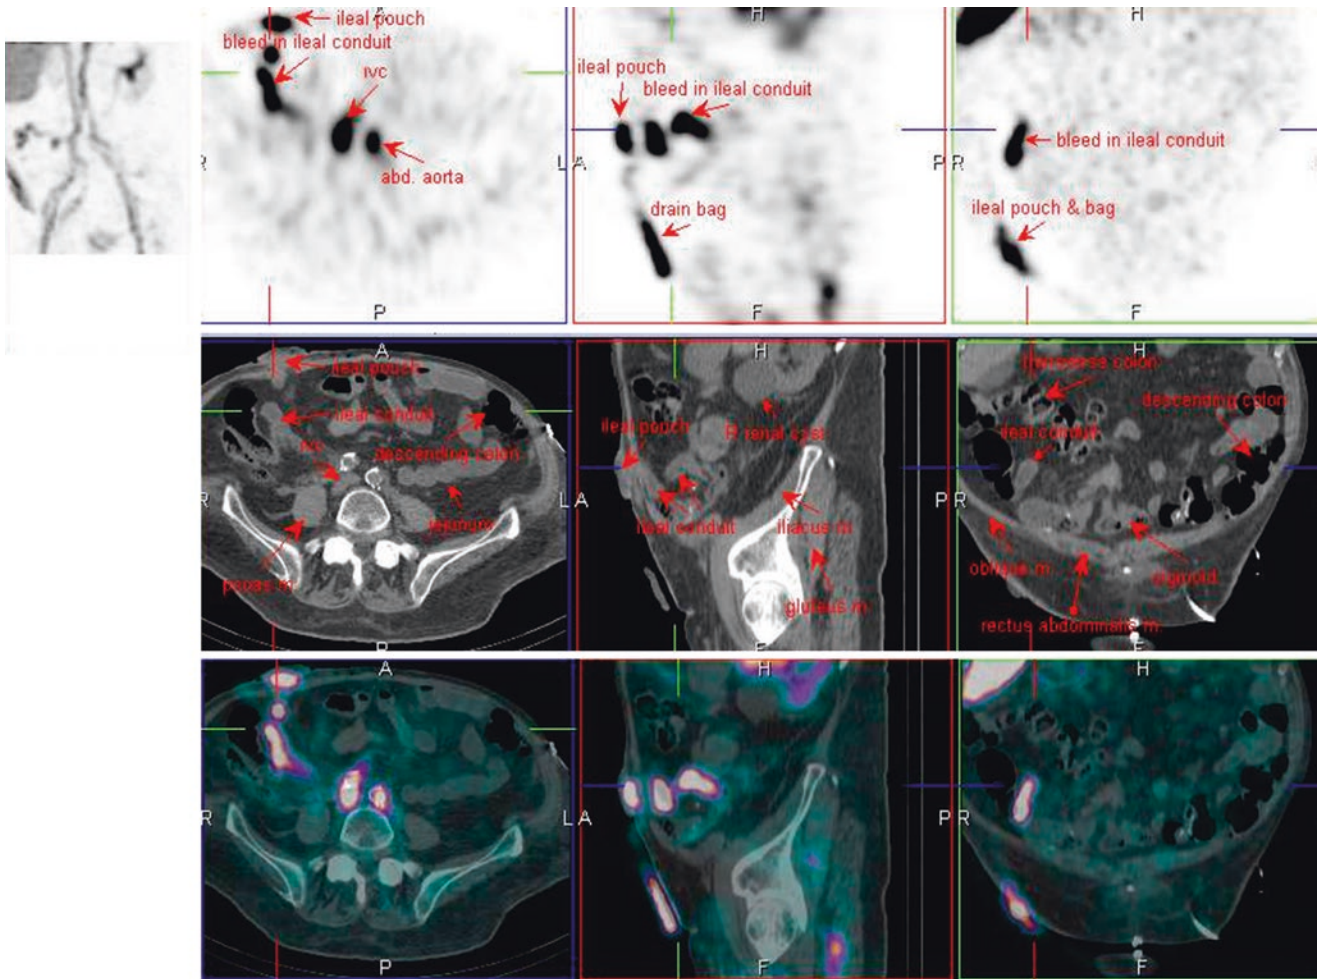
^{99m}Tc-RBC SPECT/CT
